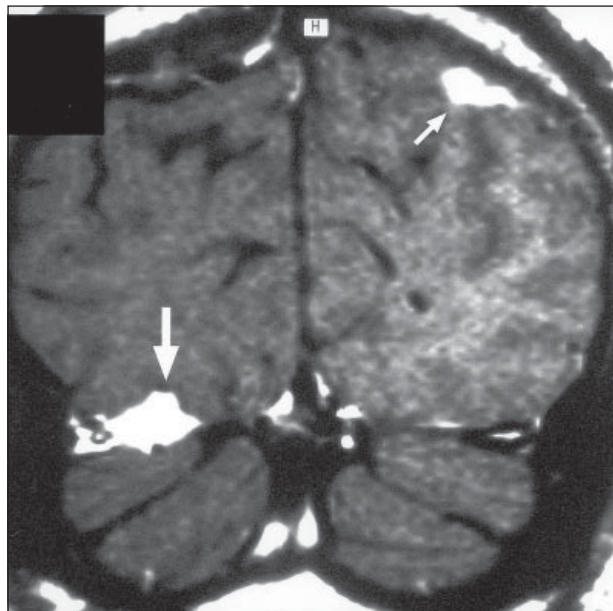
Contrast coronal magnetic resonance images of the brain show enhancing dural-based lesions at the right tentorium (large arrow) and left parietal region (small arrow).
